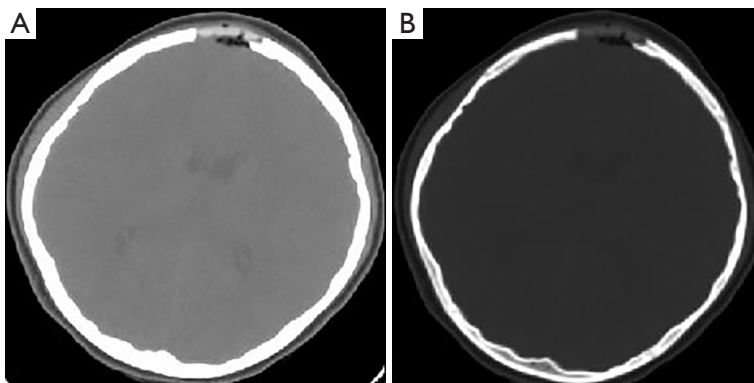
Postoperative re-examination of cranial CT: axial (A) and bone window (B) showed complete removal of the lesion. CT, computed tomography.
